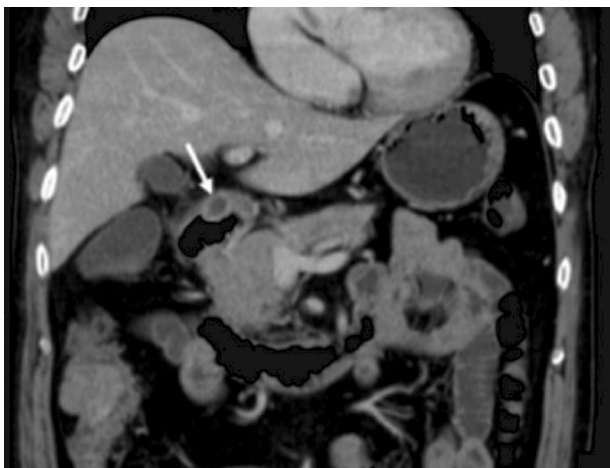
Submucosal mass of the stomach (CT)
